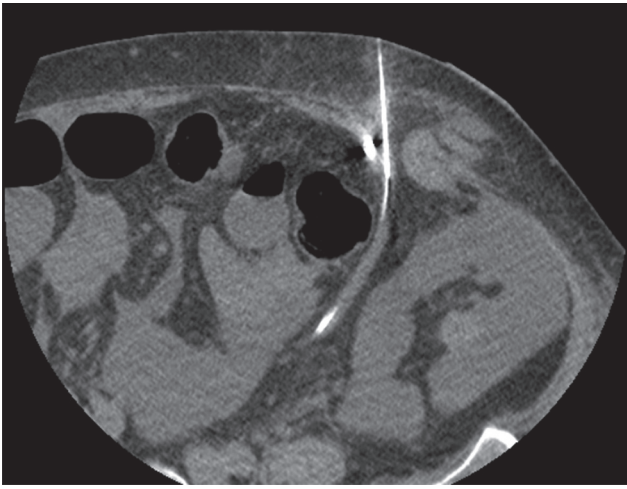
CT-guided percutaneous access of the large collateral supplying the parastomal varices.
